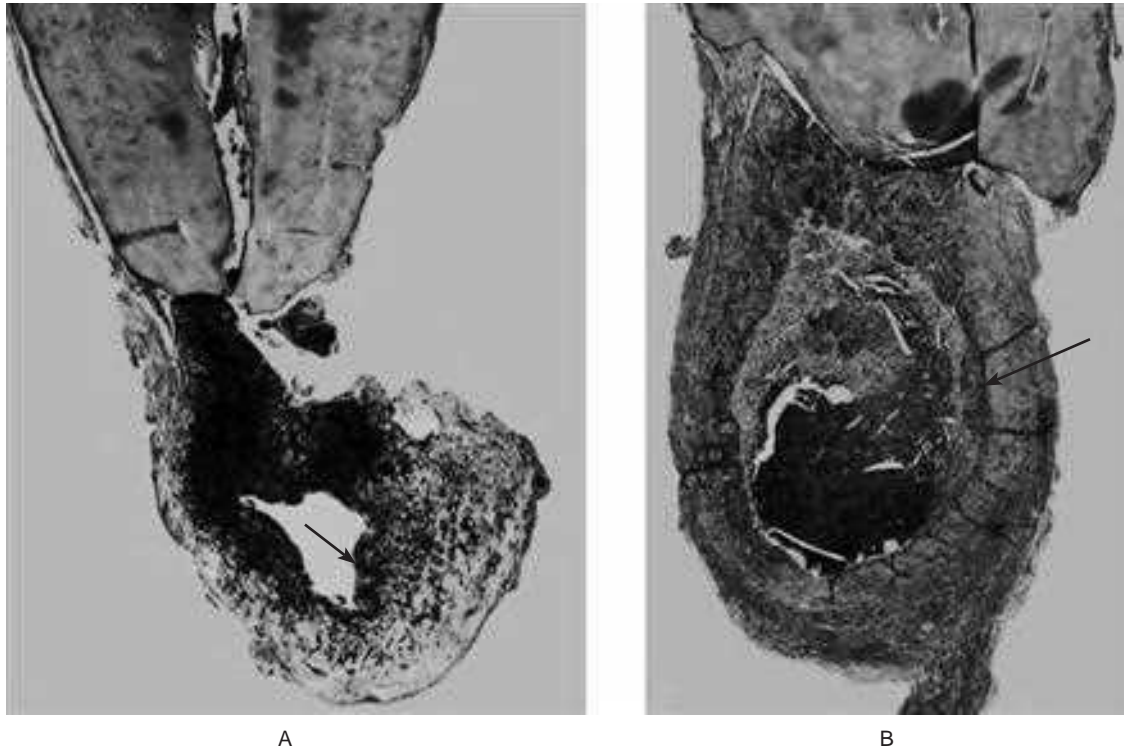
Epithelial proliferation in a periapical granuloma attached to the tooth root.
